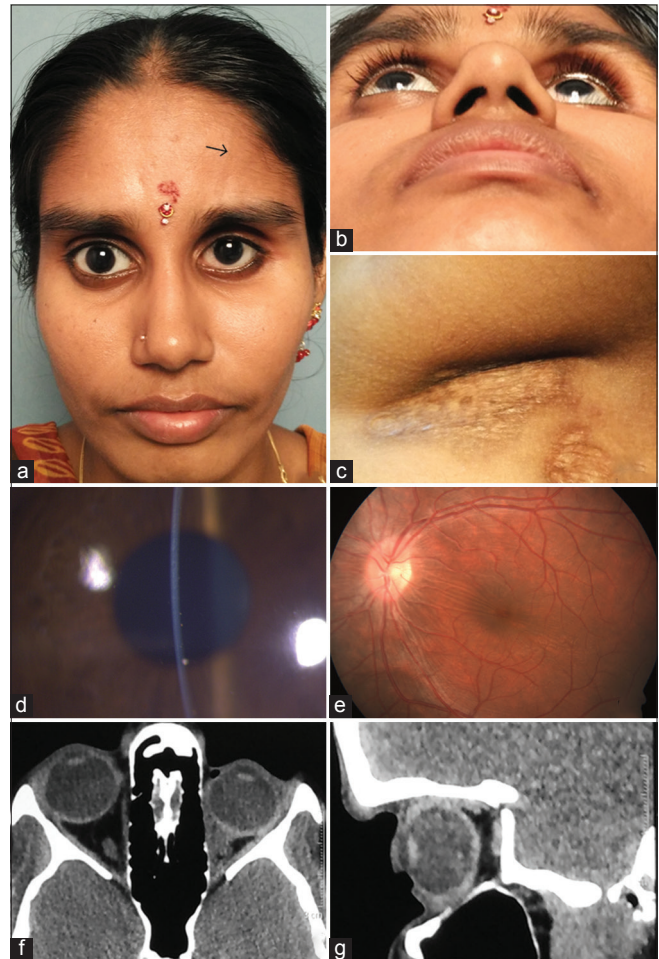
(a and b) Clinical photographs showing gross enophthalmos of left eye with linear diagonal scar over left forehead (Coup de Sabre-black arrow); (c) atrophic and sclerotic skin lesion in left inguinal region; (d) slit lamp photograph of left eye showing corneal endothelial precipitate; (e) fundus photograph of left eye showing multiple retinal folds at macula; (f and g) computed tomography scan orbit (axial and saggital section) showing enophthalmic left eye with reduced retrobulbar fat volume with absence of any other abnormality
